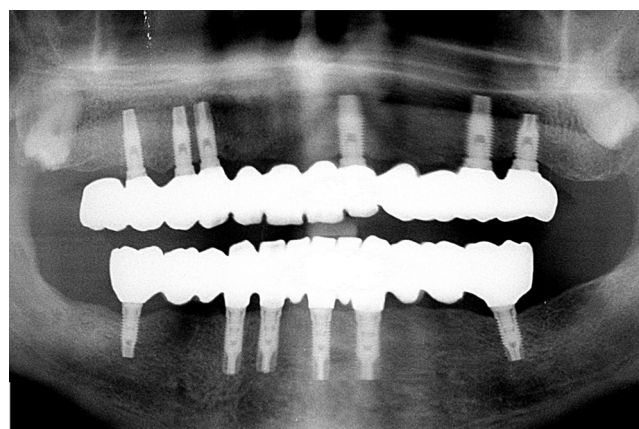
Representative panoramic radiograph of prostheses.
